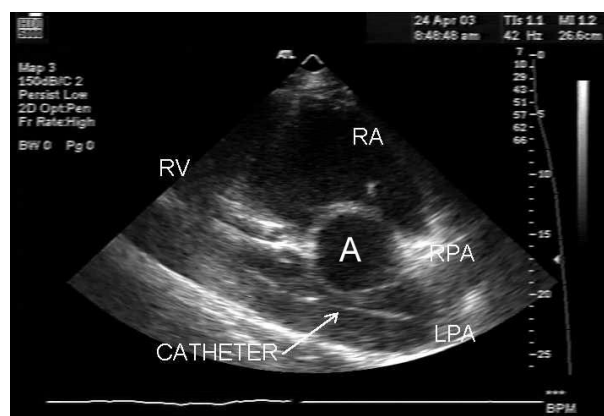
Ultrasonographic image of catheter within the pulmonary artery (PA). Right parasternal long-axis view of right ventricular outflow tract. The PA catheter can be identified as a linear echogenic object within the lumen of the PA. The catheter tip in this image is positioned at the bifurcation of the PA. A, aorta; RA, right atrium; RV, right ventricle; LPA, left pulmonary artery; RPA, right pulmonary artery.
